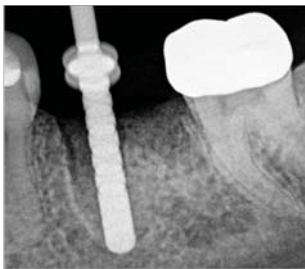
Radiograph after pilot drill
